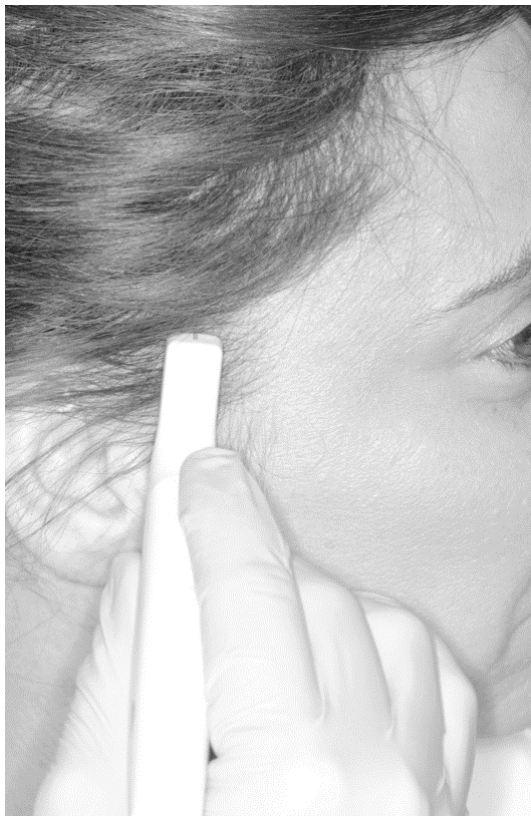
Patient and probe positioning in ultrasonography examination.
